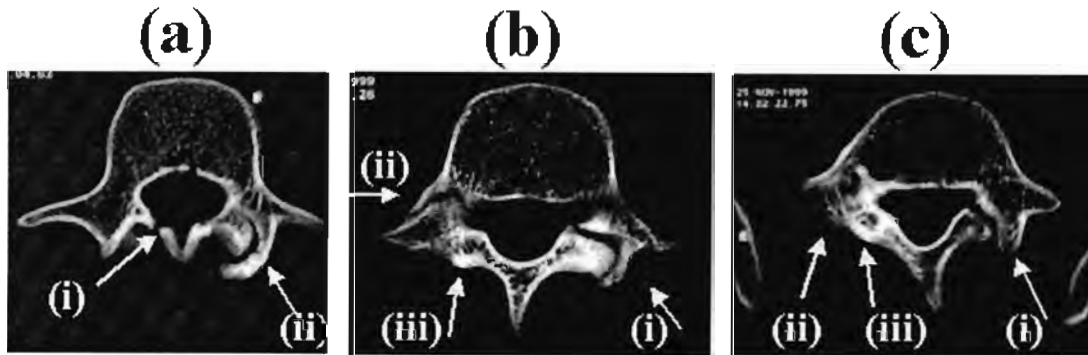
A CT scan of a 22-year-old right arm bowler of national ranking showing (a) (i) pseudo-arthrosis of the left pars interarticularis and (ii) ununited lamina fracture of lumbar 3, (b) (i) pseudo-arthrosis of the left pars interarticularis of the 4th lumbar vertebra with a partially ununited fracture through the exostosis; (ii) partial union of the right pedicle and (iii) union of the right pars interarticularis, and (c) (i) the left spondylolysis which showed a subtle area of cross trabeculation in the mid-third of the fracture line, with signs of non-bony union superior and inferior to the area of union. There is a similar bony exostosis, namely a pseudo-arthrosis. There is a slight distortion of the spinal canal at this level. healed fracture through the right pedicle with bony cortical and tubercular thickening of the 5th lumbar vertebra. (ii) There is thickening of the right pars interarticularis and (iii) a thickened, healed fracture of the right pedicle.
